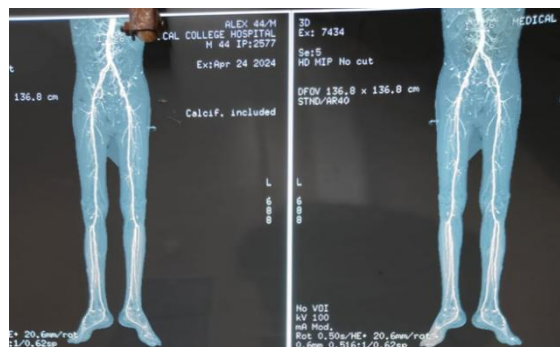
CT angiography of both lower limbs showing atherosclerotic wall thickening with circumferential intermittent calcification of infra-renal abdominal aorta causing 35% luminal narrowing. IMA at origin had ostial narrowing with 50 % luminal narrowing with a complete normal contrast opacification in the rest.
